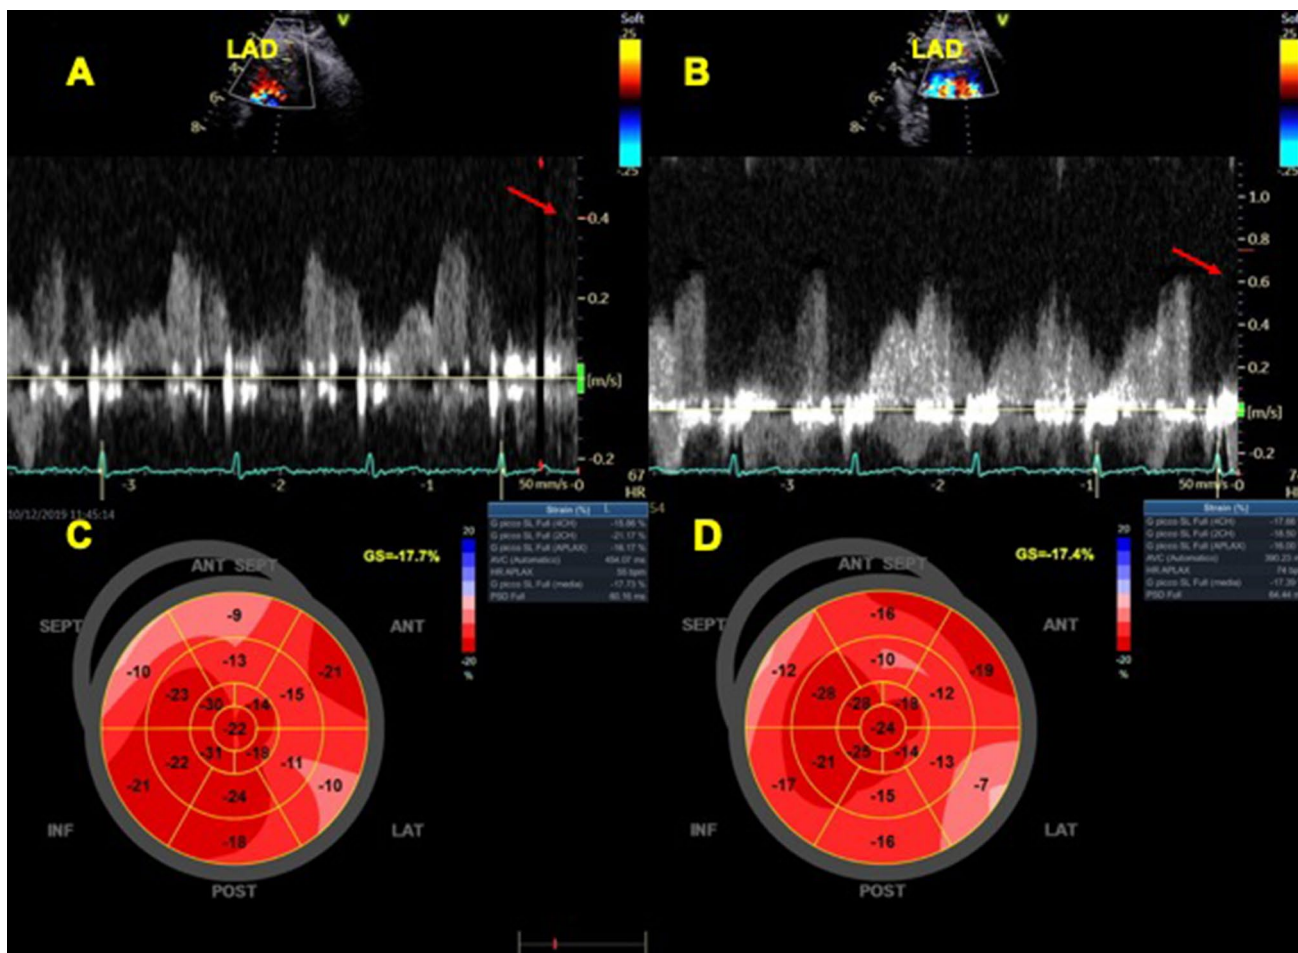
Global longitudinal strain (GLS) decrease during dipyridamole stress echocardiography in a patient with coronary microvascular dysfunction. Coronary flow is sampled in the mid-distal portion of the left anterior descending (LAD) at rest (A) and at peak stress
